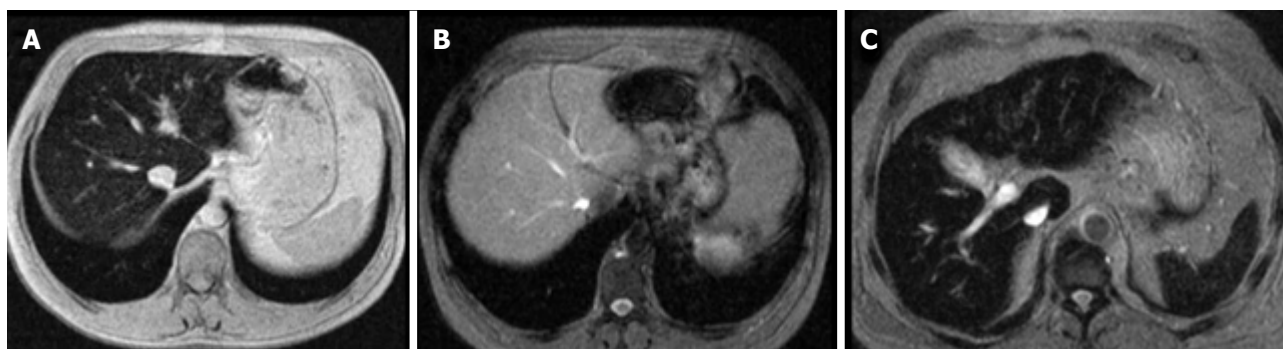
Quantification of liver iron concentration using magnetic resonance imaging. A: Hereditary hemochromatosis. Liver iron overload: Important reduction in signal intensity from the liver; B: Prolonged treatment with phlebotomies. Liver signal intensity is normal; C: Secondary hemochromatosis. Reduction in signal intensity in the liver and the spleen.
